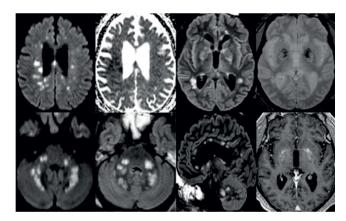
65-year-old man with pathological wakefulness. Non-confluent white matter hyperintense lesions on FLAIR and diffusion and hemorrhagic lesions. Multiple nodular hyperintense in the white matter including corpus callosum (F). Some with reduced ADC corresponding to cytotoxic edema (C). (E, G, H), with hemorrhagic changes (G), contrast enhancement. Figure reproduced with permission from Kremer S et al. (2020); copyright 2020 RSNA. doi.org/10.1148/radiol.2020202222
